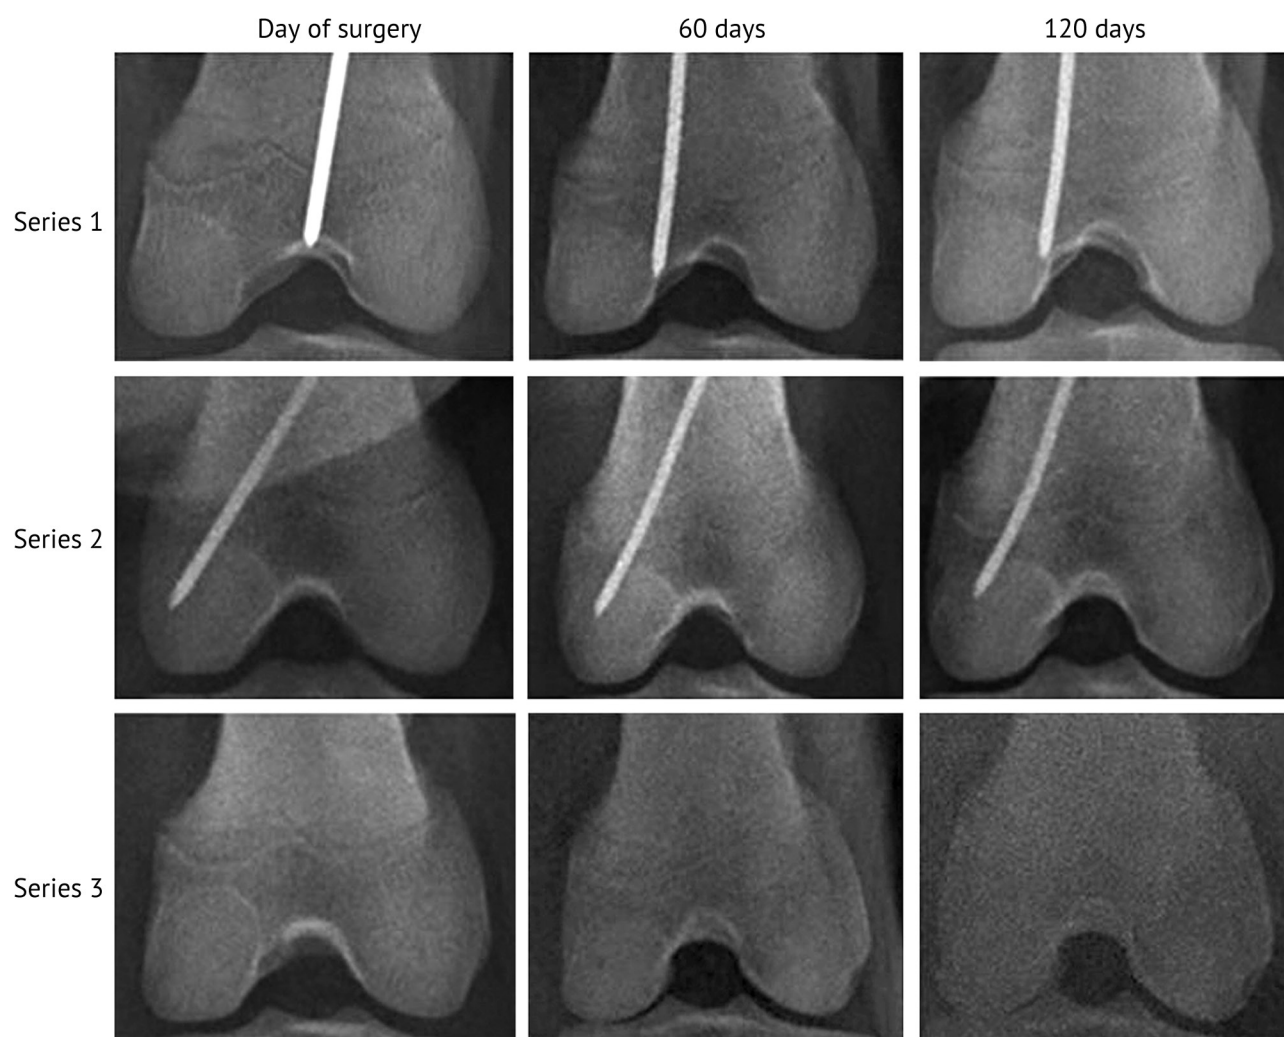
Radiographic images of wires/pins in the femoral metaphyses at the time-points of the experiment
